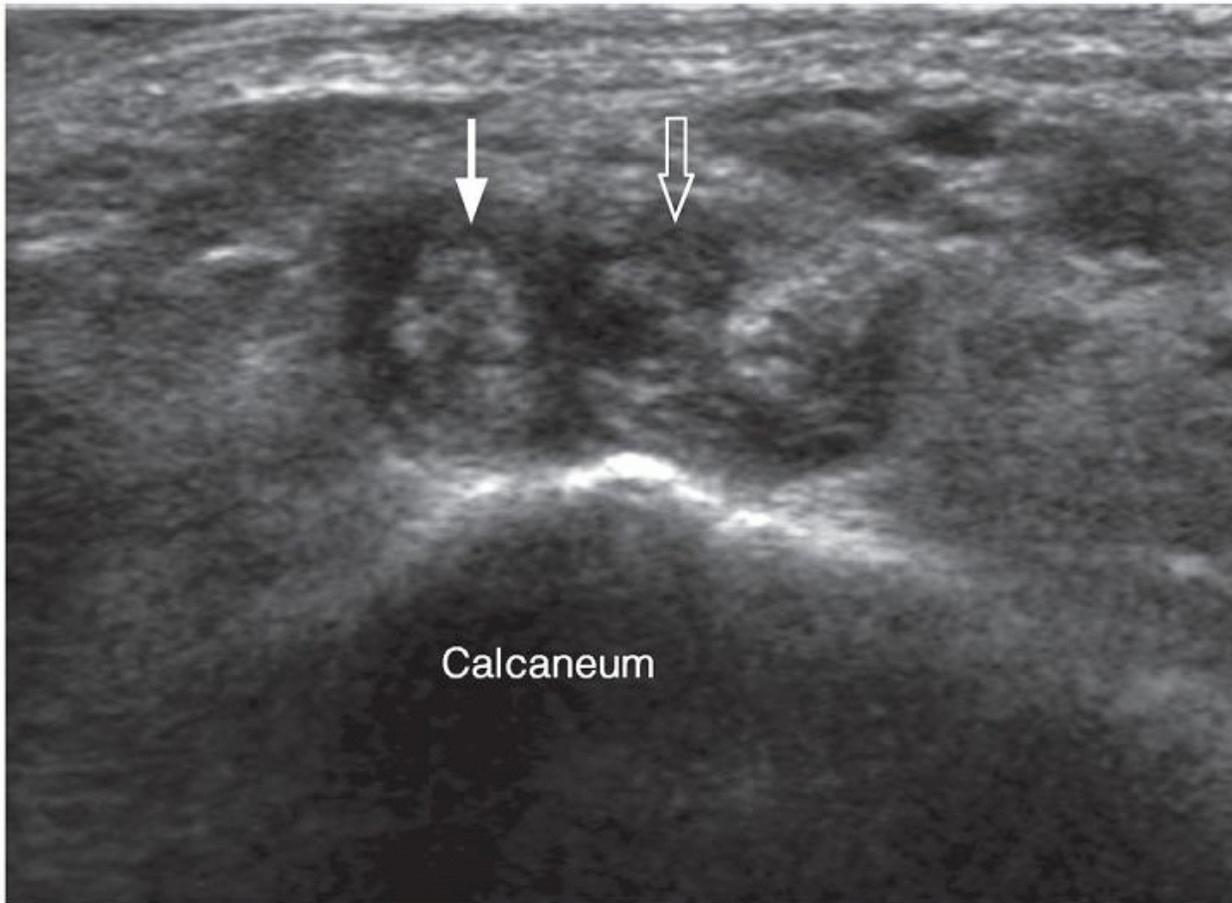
Transverse ultrasound lateral aspect of the hindfoot just distal to lateral malleolus. There is moderate to severe tendinosis of the peroneus longus (open arrow) and peroneus brevis tendons with tendon enlargement, heterogeneity, longitudinal tears (closed arrow), and irregular margin.
